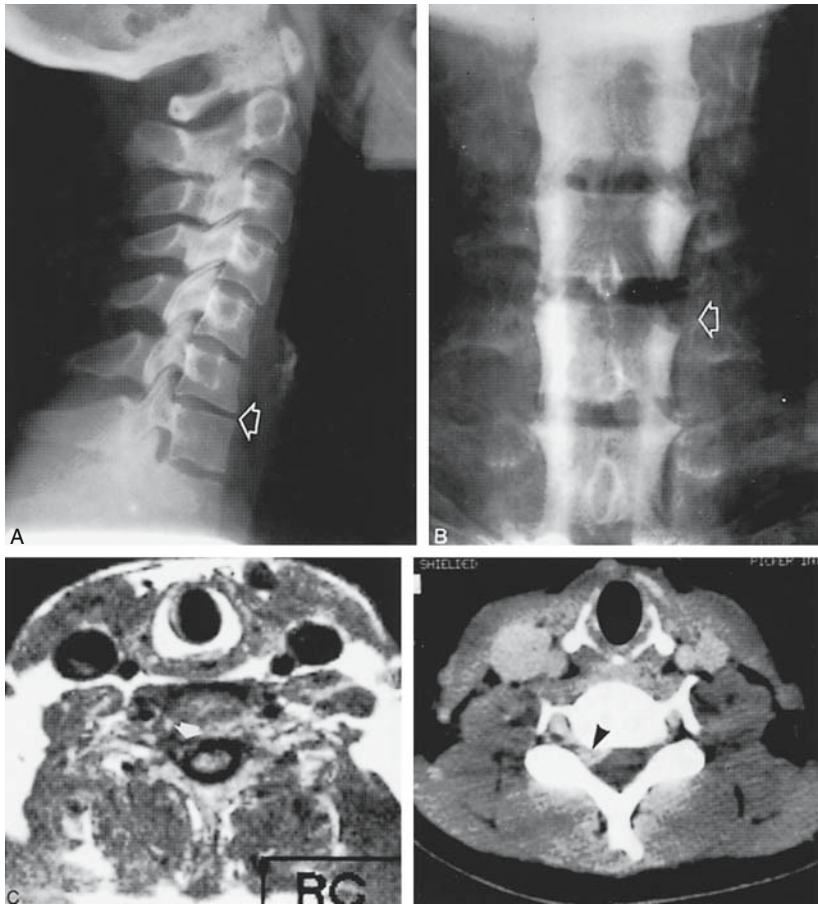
This 33-year-old man presented with right triceps weakness, C7 radicular pain, and absent triceps reflex. (A) Lateral radiograph of C6–C7 shows loss of disk height (*arrow*). (B) Anteroposterior myelogram confirms right C7 root sleeve cutoff. (C) Axial magnetic resonance imaging (*left*) and computerized tomography (*right*) show occlusion of the right C6–C7 foramen (*arrows*). (From Boden S, Wiesel SW, Laws E, et al. *The Aging Spine*. Philadelphia: Saunders, 1991. Reprinted by permission.)
